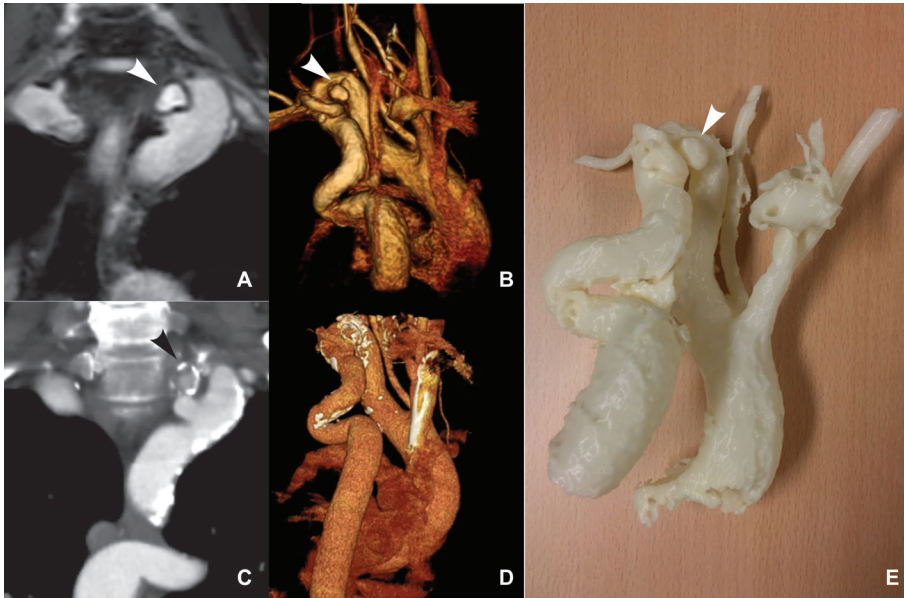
Example of noncontrast-enhanced water-fat resolved Dixon MRA of the thoracic aorta: a 66-year-old man, known with a cervical aortic arch (type C: left cervical arch with right-sided looping descending aorta). (A,B) Dixon water-image: (A) enlarged coronal view of the cervical aortic arch and (B) posterior view of the 3D visualization of the aorta. Note the aneurysm at the cervical loop (white arrows) (C,D). For comparison, contrast-enhanced CT images are provided: (C) enlarged coronal view. Note the calcified wall of the aneurysm (black arrow); (D) posterior view of the 3D visualization. (E) Posterior view of the 3D print, based on Dixon MRA of the aorta.
